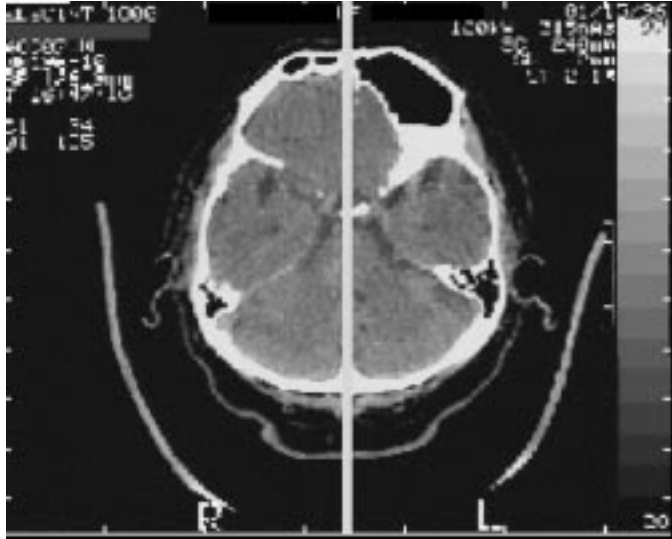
The midsagittal plane automatically extracted from a clinical CT image where obvious asymmetry is present.
